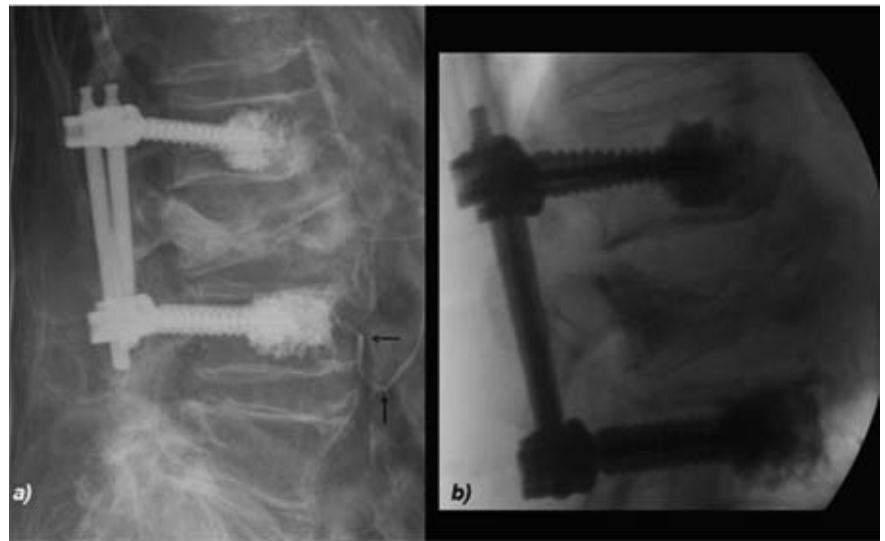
Bone cement migration (arrows) is seen at the postoperatively radiograph (a) but not at the intraoperatively one (b). Note the quality difference between both radiographs.
